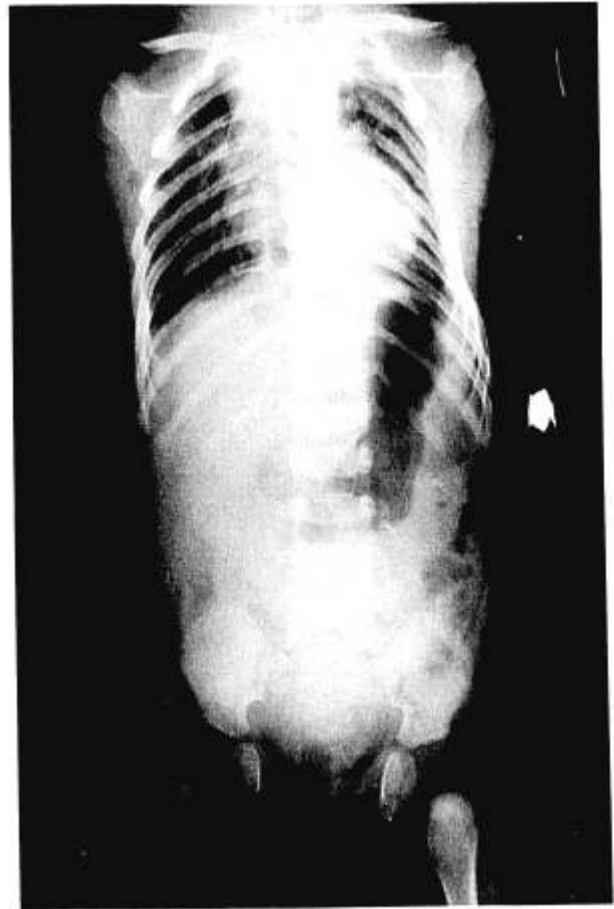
Whole body radiograph immediately after the operation in "twin A."
